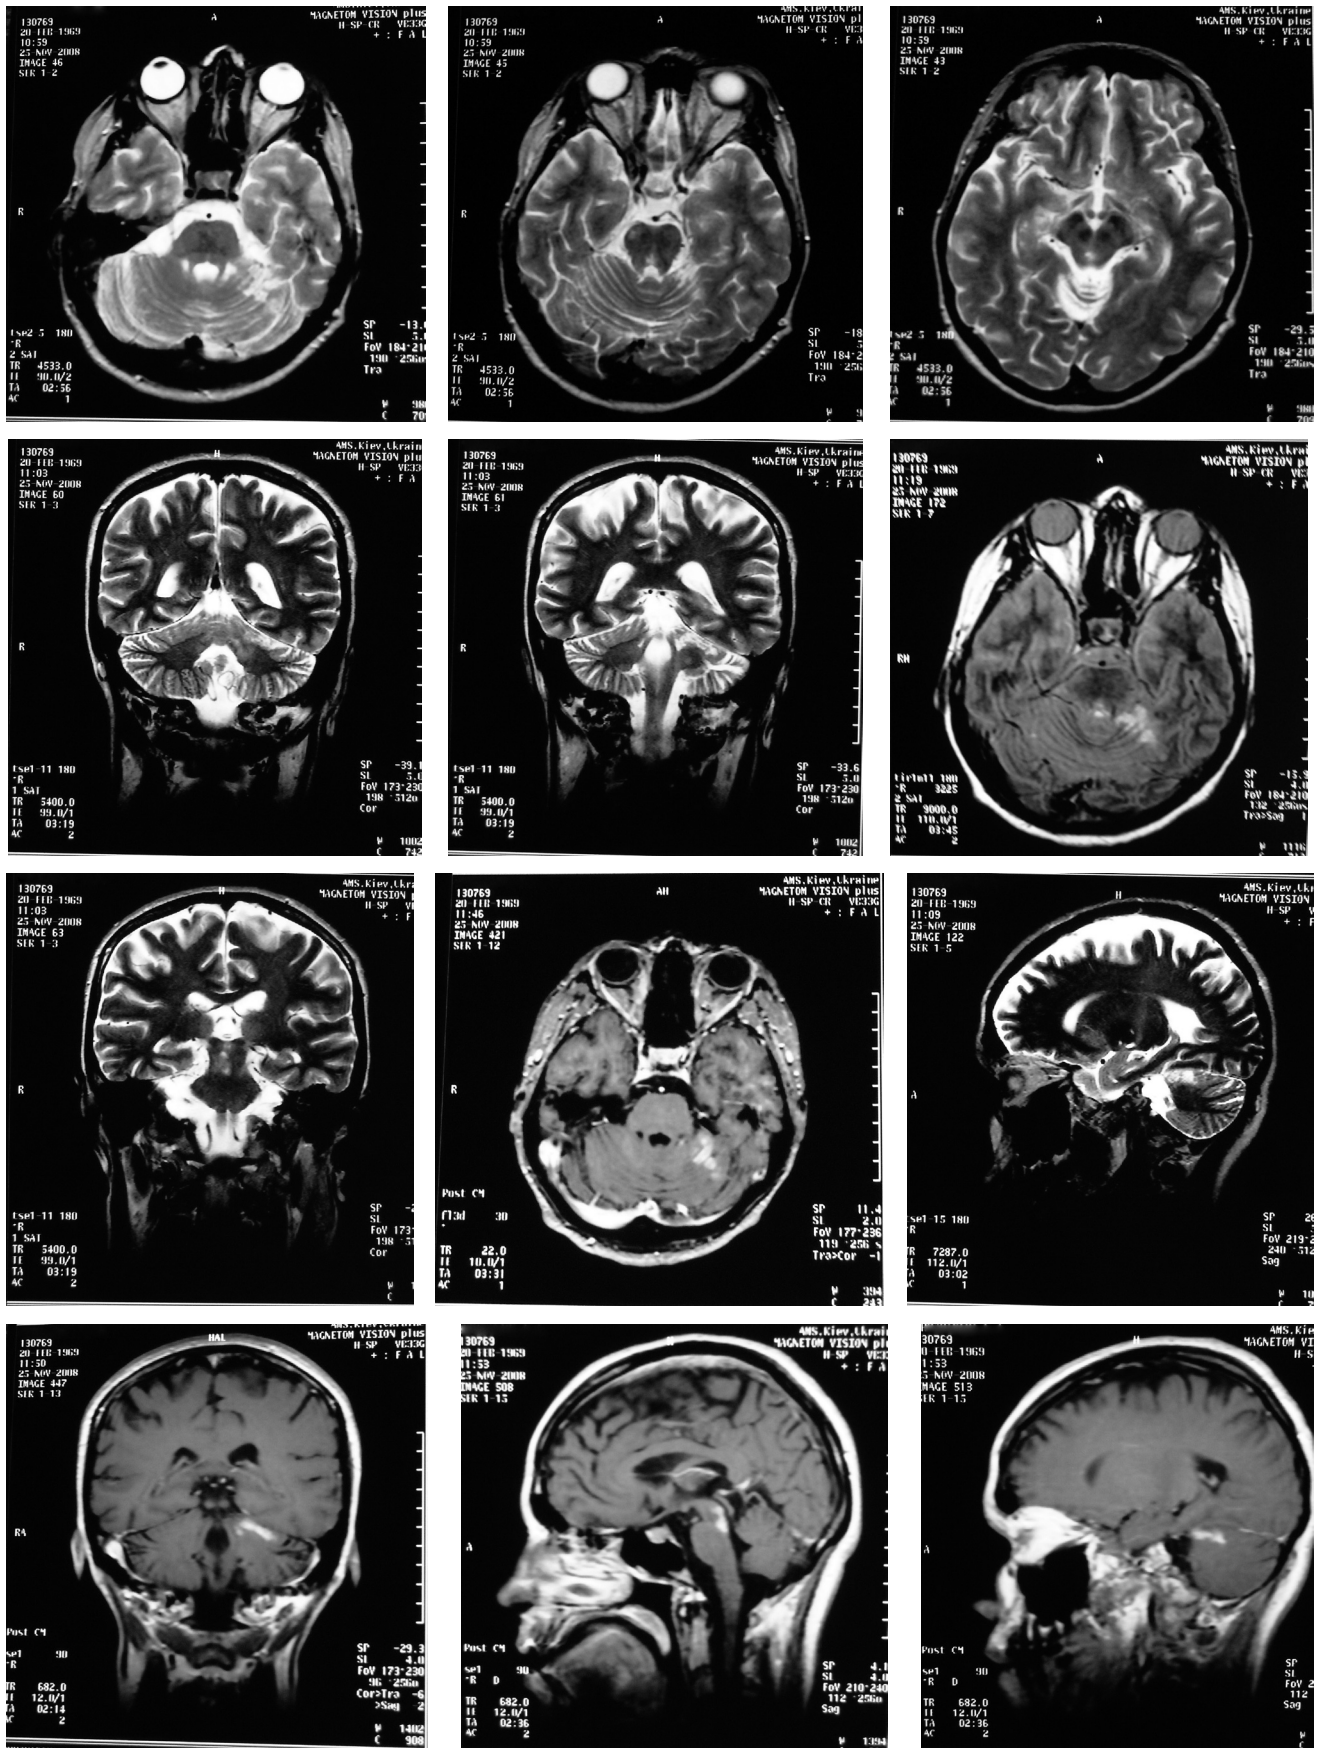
MRI imaging of the brain of patient S., 39 years old. T2- (Fig. 1 a-f, h), FLAIR (Fig.1 g) shows bilateral foci of increased intensity of the MR signal in the parenchyma of the cerebellum and dorsolateral parts of the pons (basilar artery basin), which is on T1 + C (Fig.1 h-l) in the left cerebellar hemisphere demonstrates contrast enhancement.
